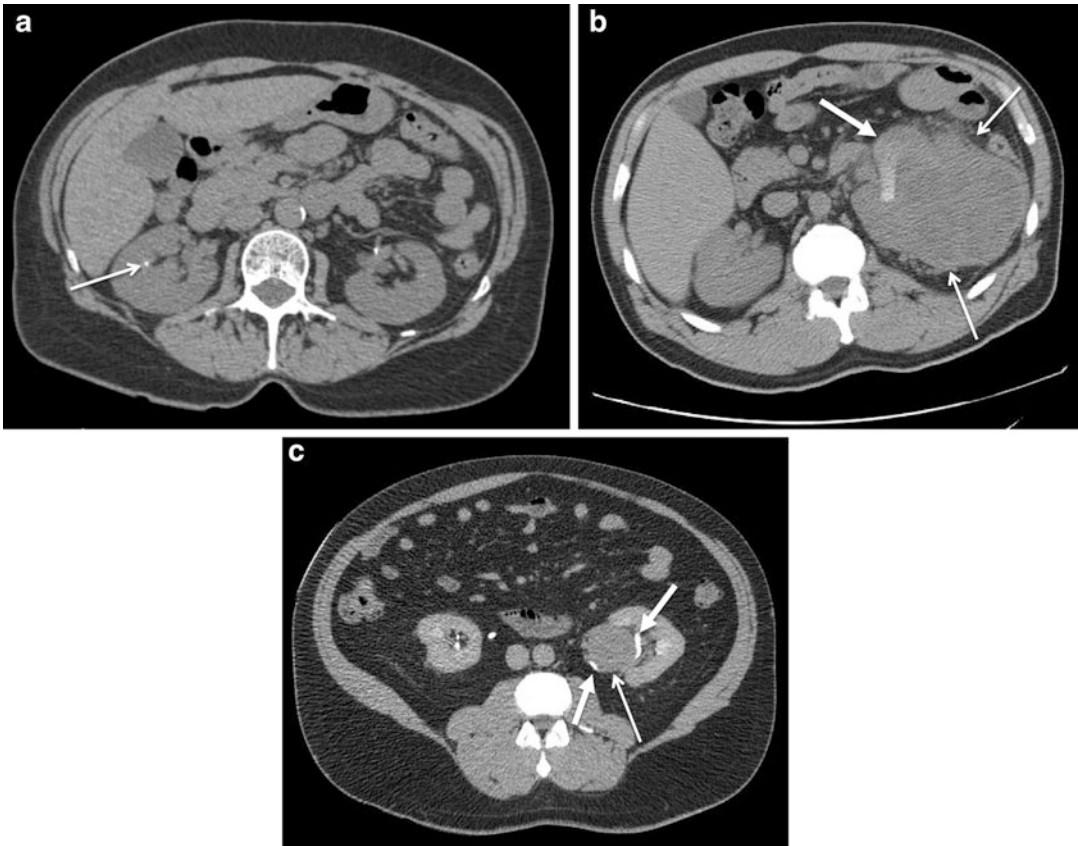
Examples of CT images. (a) An axial image from a CT of the abdomen and pelvis without either oral or intravenous contrast shows a punctate, nonobstructing right renal calculus (*arrow*). (b) Another unenhanced CT image in a different patient with a chromophobe-type RCC demonstrates a large, heterogeneous mass (*arrows*) replacing the left kidney; hyperdense material in the left
